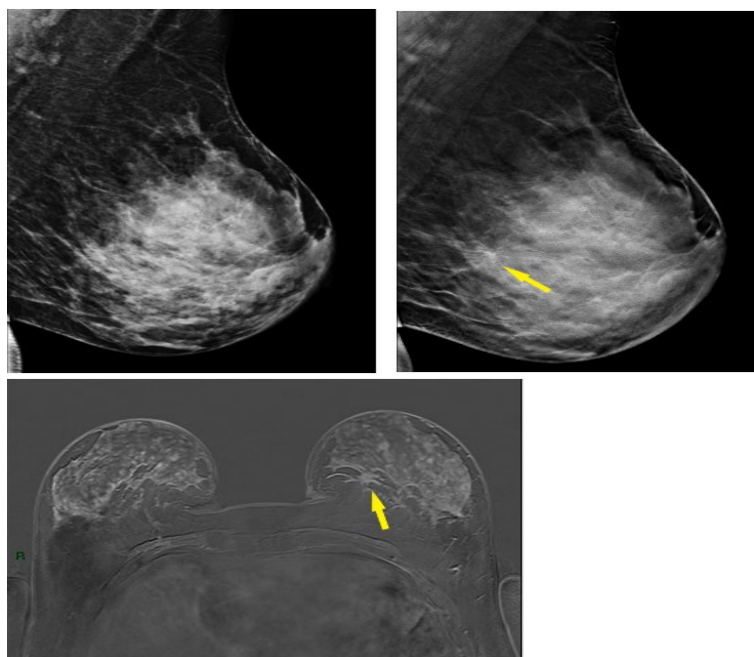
A case of a 47-years old women with a extremely dense breasts (ACR D) and a HP verified radial scar. A) DM in MLO projection image does not show any lesions in left breast, B) DBT image in MLO projection shows a spiculated lesion prepectoral in lower inner quadrant of left breast, C) MR axial 3D T1W FLASH FS image shows a spiculated mild hyperintense lesion prepectoral in inner quadrant.*Ultrasound images are not available because there is not an archive of ultrasound images at our Institution.
